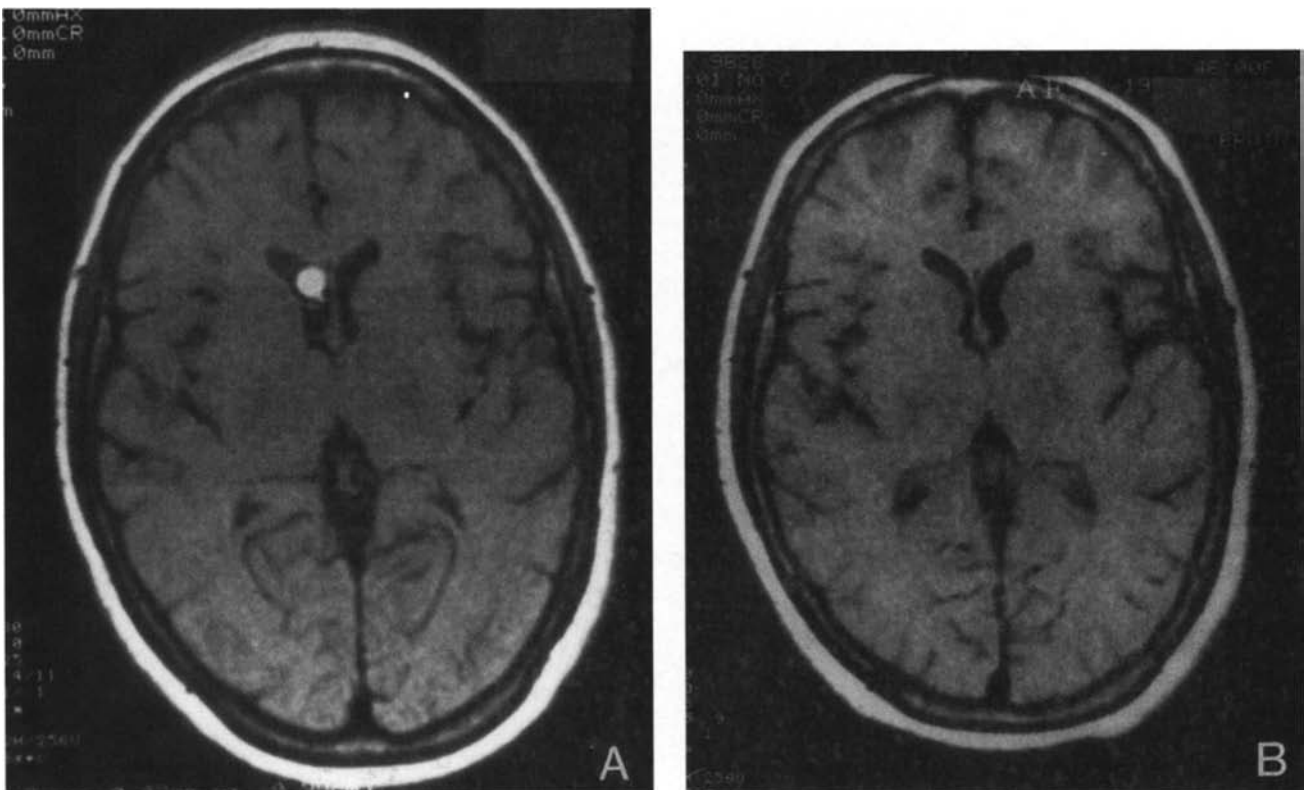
A*, T₁-weighted MRI shows an intraventricular cyst in the frontal horn of the right lateral ventricle. *B*, T₁-weighted MRI performed 13 months later shows resolution of the intraventricular cyst. The patient was a 53-year-old woman who presented with recurrent tonic clonic generalized seizures.
